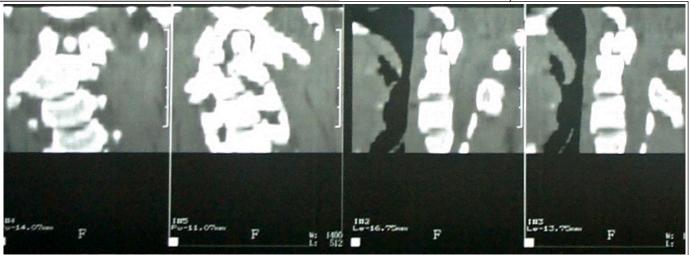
CT scan showing shear fracture of C-2 body with intact dens and subluxation of C1-C2 joint on left side.
